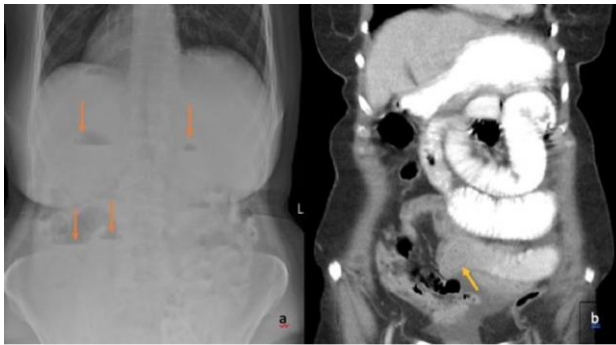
The patient's preoperative abdominal X-ray (a) and CT scan (b) coronal plane
